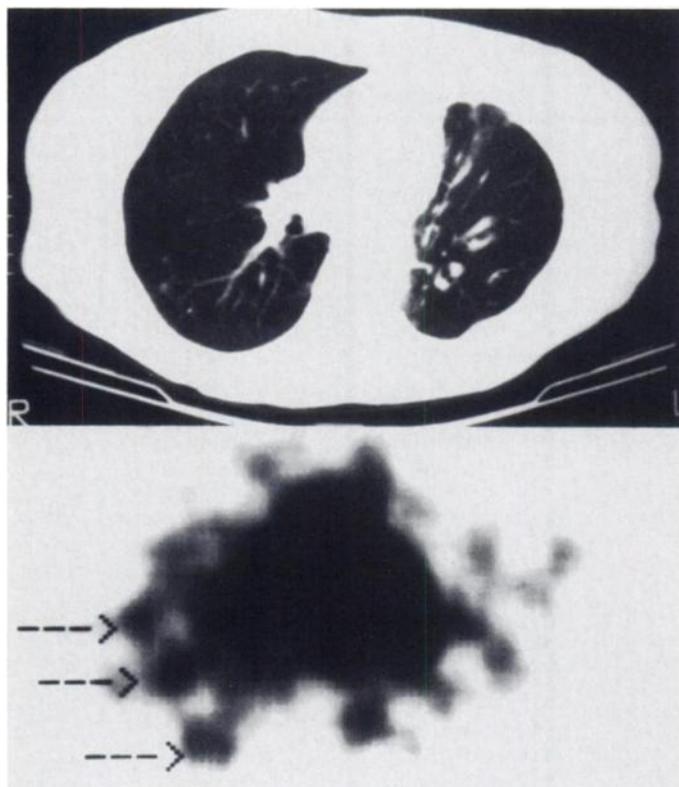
CT of the chest demonstrating three small pulmonary nodules (arrows) in the right lung. A transverse SPECT section corresponding to the CT shows targeting of these nodules with ^{131}I NP-4 F(ab')₂. Note that the nodules appear larger on SPECT (and apparently less intense) due to the limited spatial resolution of the gamma camera.
